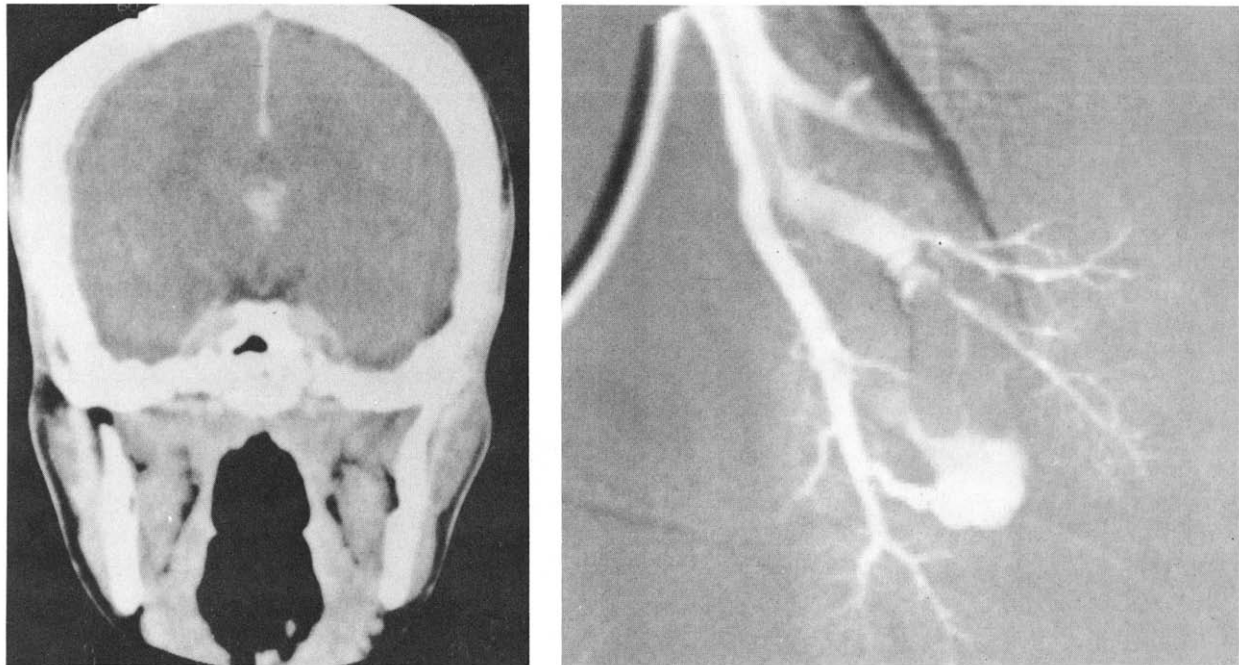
Case 16 (Rendu-Osler-Weber syndrome). (Left) CT scan with contrast enhancement shows the third ventricular AVM. (Right) Right pulmonary angiogram shows an AVM in the lung.
